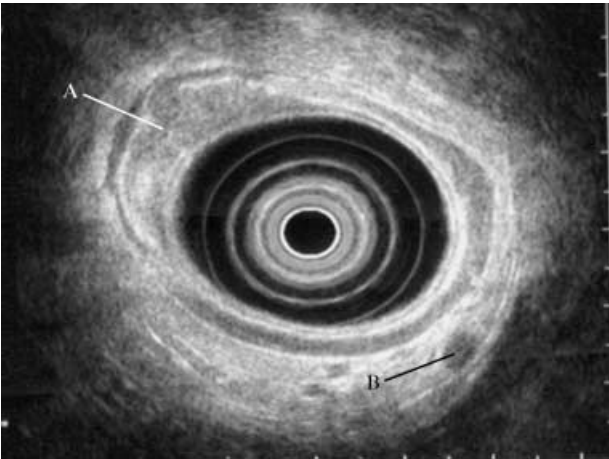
Endoscopic ultrasound appearance of T2 gastric cancer. Involvement of the muscularis propria was present (A) and there was a round hypoechoic lymph node suspicious for malignancy (B).
